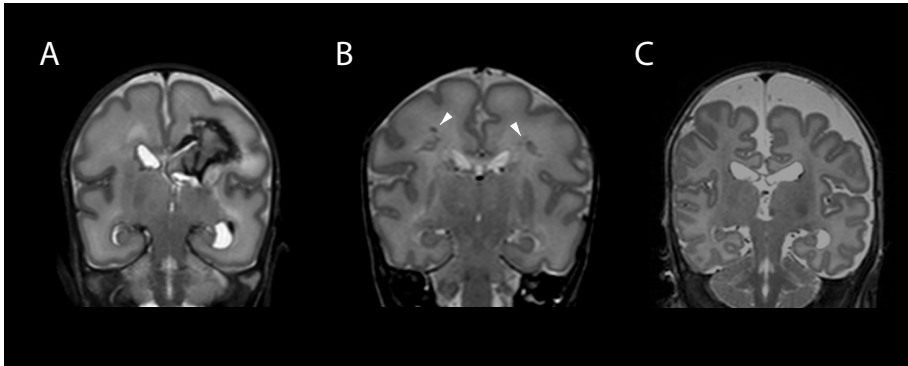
Various types of white matter injury in the preterm neonate as demonstrated by T1-weighted MRI scans. A. Periventricular hemorrhagic infarction has led to severe injury (porencephalic cyst) in the periventricular white matter. B. Punctate white matter lesions (arrowheads) in the preterm brain. C. Extreme case of diffuse white matter injury at term equivalent age of a neonate born at 23 weeks gestational age. White matter atrophy has resulted in ventriculomegaly, thinning of the corpus callosum and large amounts of CSF around the brain.
